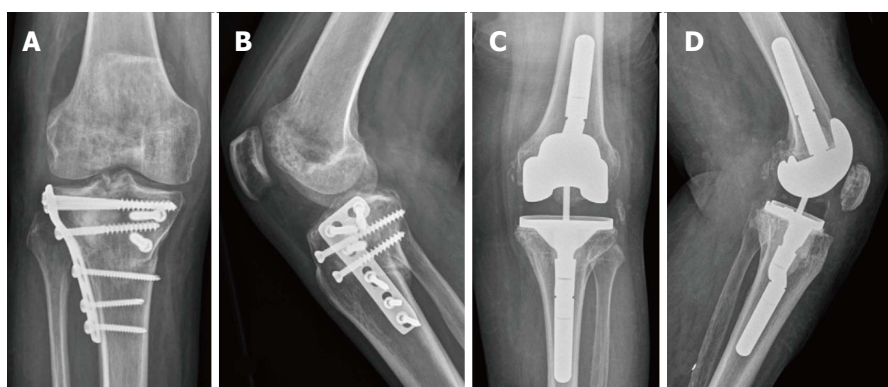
Total knee arthroplasty following open reduction and internal fixation of the tibial plateau. A and B: Radiographs of a 61-year-old woman made 3 years after ORIF for tibial plateau fracture; C and D: Radiographs at 7-year follow-up after constrained PS prosthesis with offset and stem in both components. ORIF: Open reduction and internal fixation.
